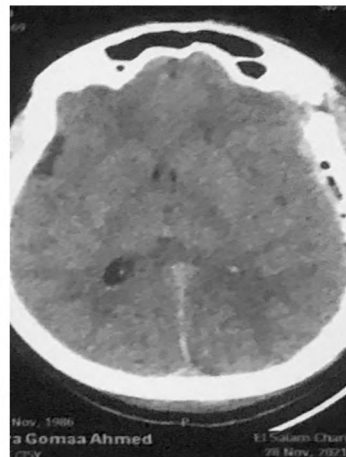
Post-operative CT brain.
